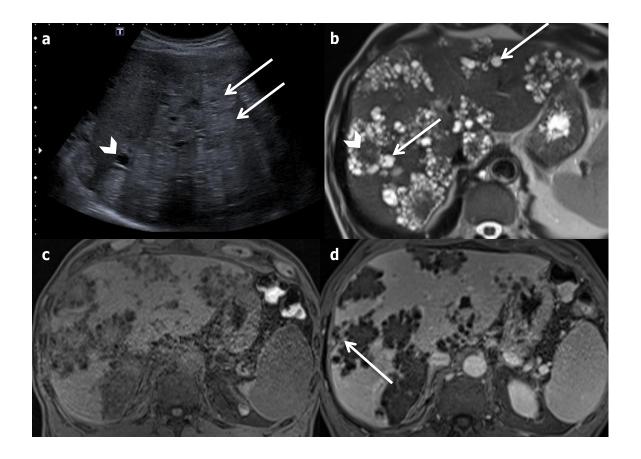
Hepatic alveolar echinococcosis in a 40-year-old male patient. (a) Ultrasonography shows multiple round hyperechoic nodules (arrows) with cystic anechoic parts (arrowhead). (b) At axial T2-weighted magnetic resonance imaging, the lesions appear as multivesicular cystic masses (arrows) with fibrous component (arrowhead). (c and d) Axial non-enhanced and at late-phase T1-fat-sat-weighted magnetic resonance imaging: the fibrous part is enhancing at late phase (arrow).
